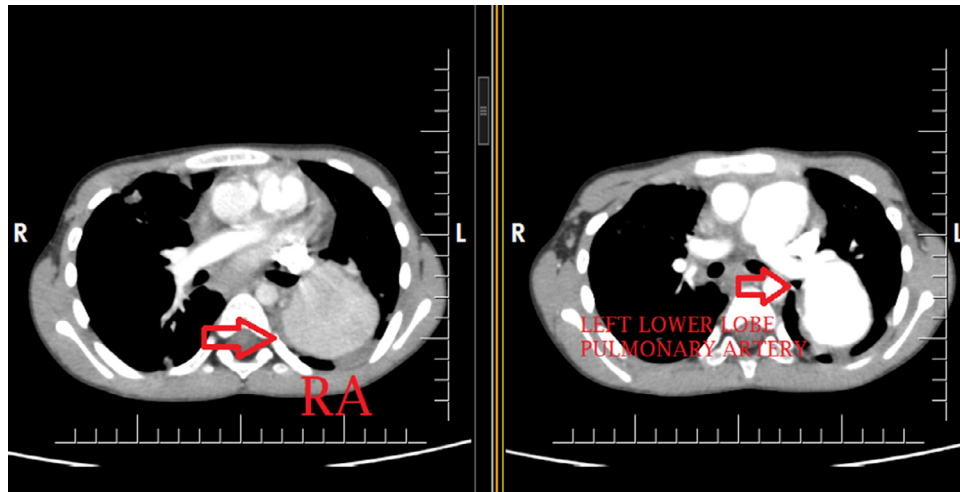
Chest CTA showing the RA to arise from the left lower lobe pulmonary artery.
